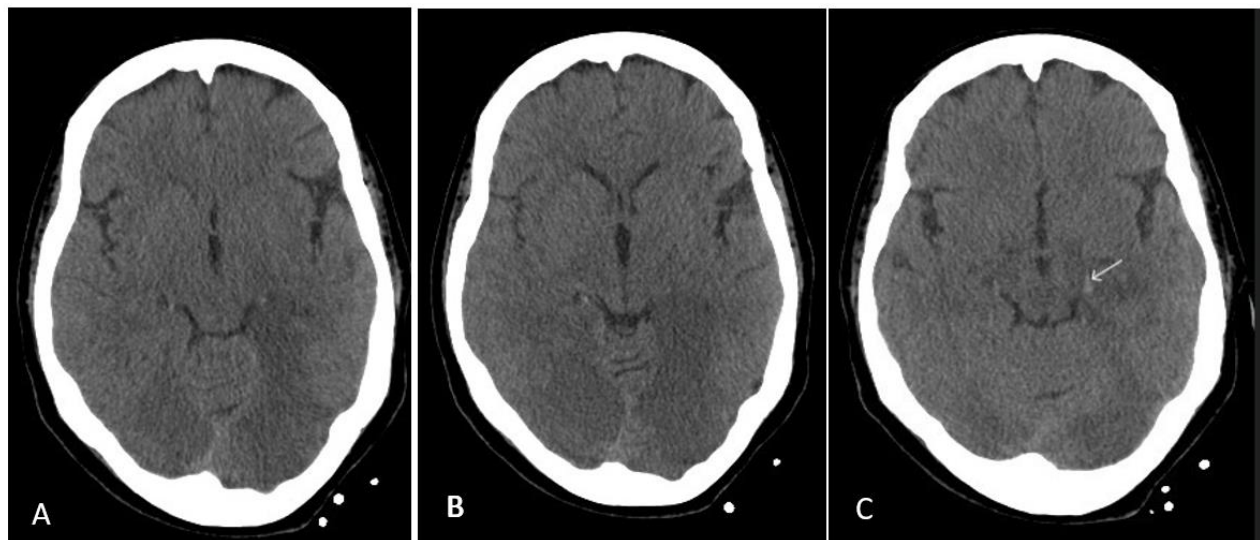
CT scan which objectified the presence of 2 hypodense lesions in spontaneous contrast at the level thalamic bilaterally (A to B), with hyperdense left P2 PCA sign (arrow) (C)
